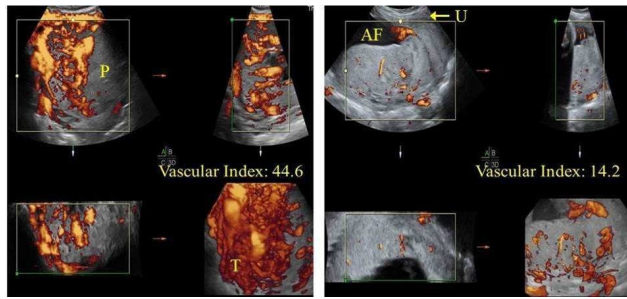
Ultrasound comparison of 3D Doppler placenta between MAP with percreta (left) and No MAP (right), P, placenta; AF, amniotic fluid; U, uterine wall; T, tortuous vessels
